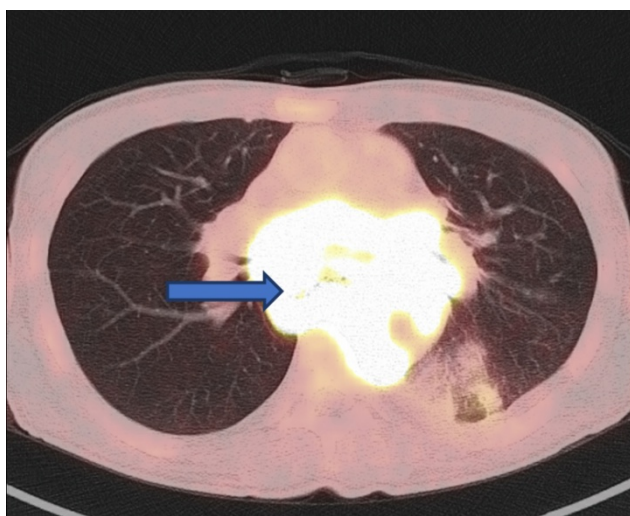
PET/CT scan that showing a large hypermetabolic mass in the mid to distal esophagus consistent with malignancy
